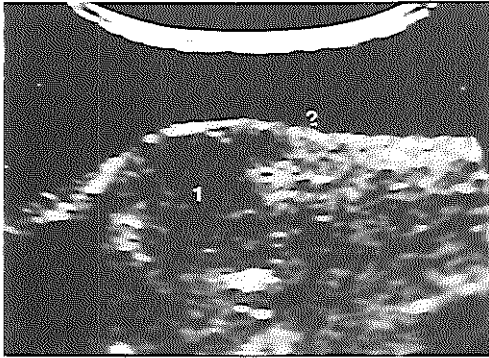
Ultrasound appearance of a 'collar stud' abscess in cervical tuberculous adenitis, demonstrating spread into the subcutaneous tissues.
